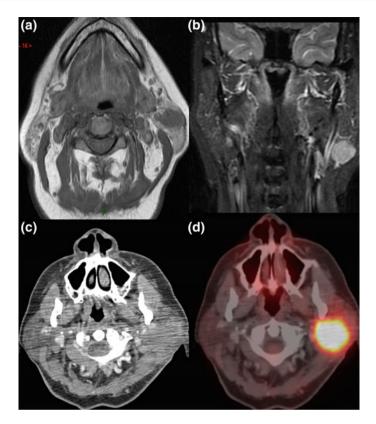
Lymphoma. a Axial T1. b Coronal T2 fat suppression. c Contrast-enhanced CT. d PET-CT. Notice how the tumor is readily distinguishable in a and b from the normal left parotid gland. Figure 5.8c, d are images 1 month later demonstrating interval growth of the tumor. The lesion is more infiltrative and less discernible on CT than MRI
